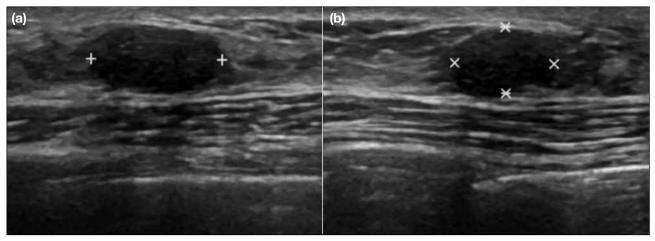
(a, b) Ultrasonogram showing an oval circumscribed parallel hypoechoic mass, which was the most commonly encountered finding in our patient cohort. Fine needle aspiration was performed for this mass with cytology confirming fibroadenoma.
